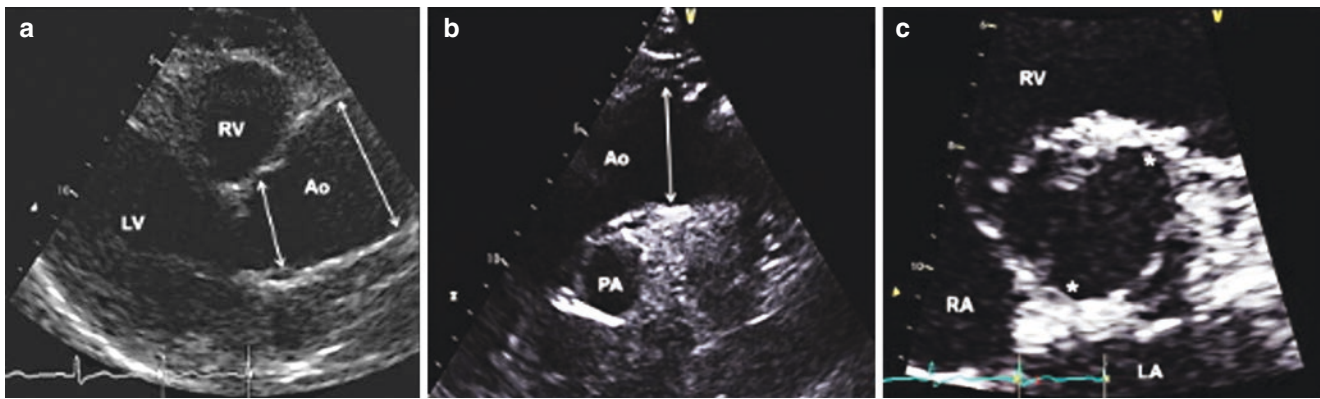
Transthoracic echocardiogram of a 60-year-old woman with bicuspid aortic valve. Images show (a) parasternal long axis view showing aortic aneurysm with dilated root measuring 3.6 cm (first arrow from the left) and mid-tubular ascending aorta measuring 4.7 cm (second arrow from the left). (b) Suprasternal view showing mildly dilated
